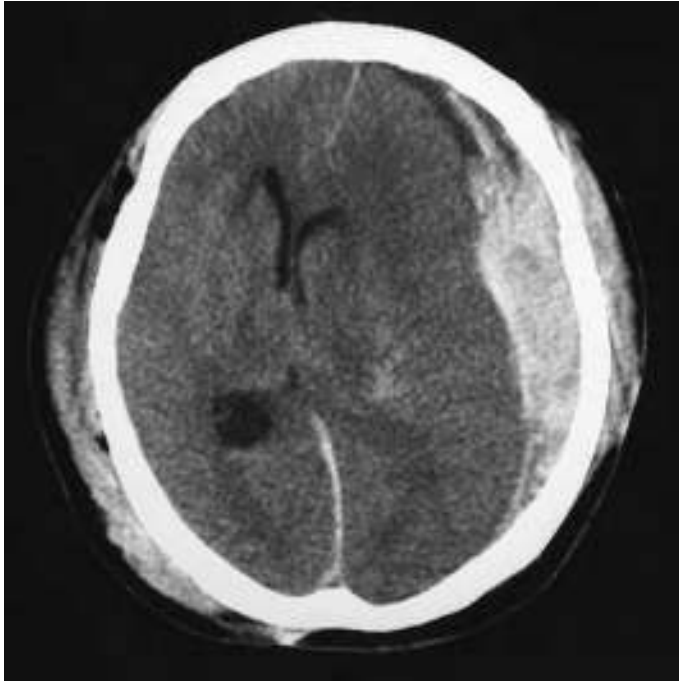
CT scan image of a subdural hemorrhage.
